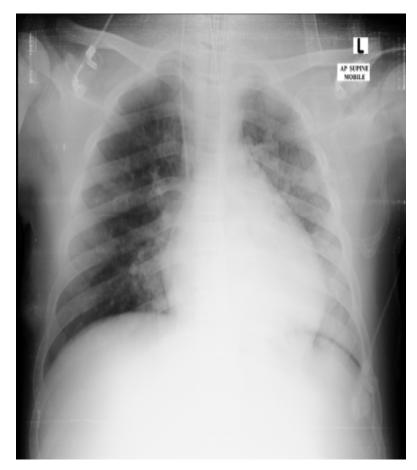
Chest X-ray showing acute respiratory distress syndrome picture.
